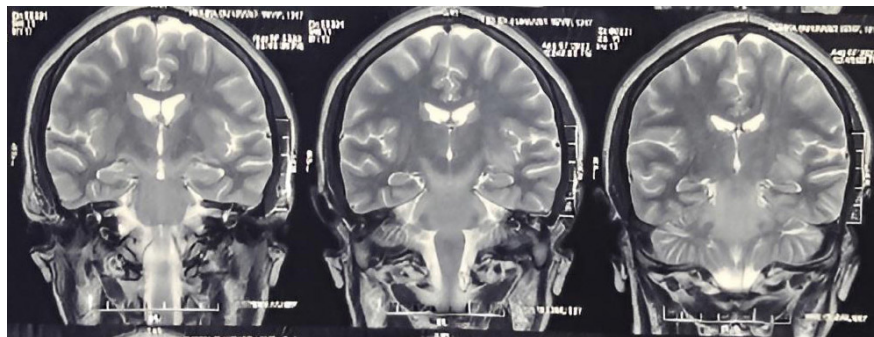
Hyperintense T2/FLAIR coronal images on left insular lobe and adjacent thalamus.
